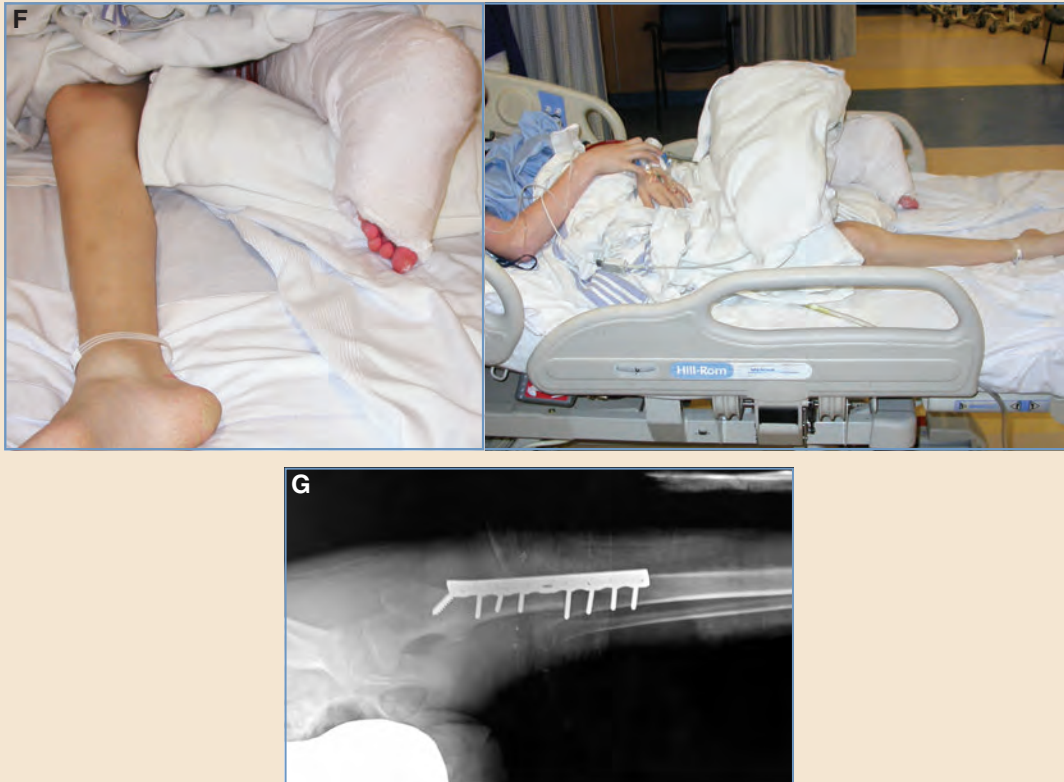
cont'd F, The postoperative position shows rotation of leg. G, A radiograph of the femoral-tibial plating.
